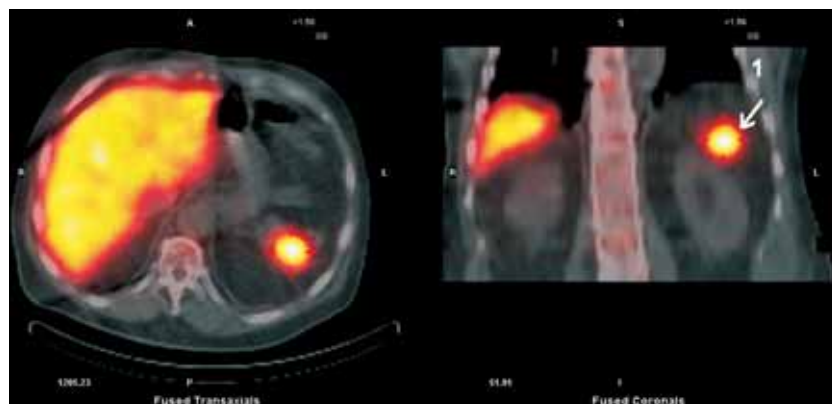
SPECT/CT images. Radiotracer uptake in the left renal space.
